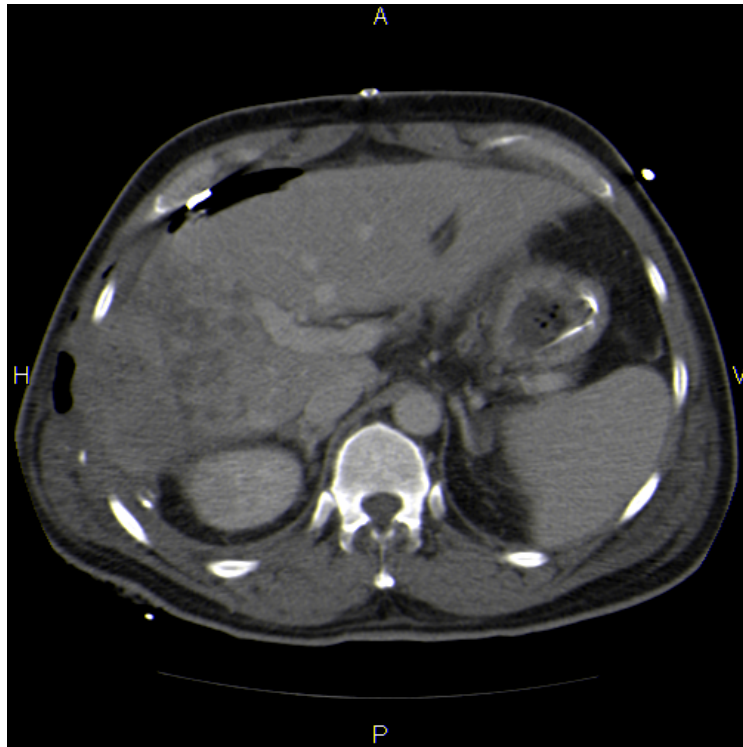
The crushed liver with hemostatic packing as it was be Demonstrated by CT on arrival in the trauma center three days post trauma. Multiple lacerations from the dome of the liver down to the hilum can be seen.
